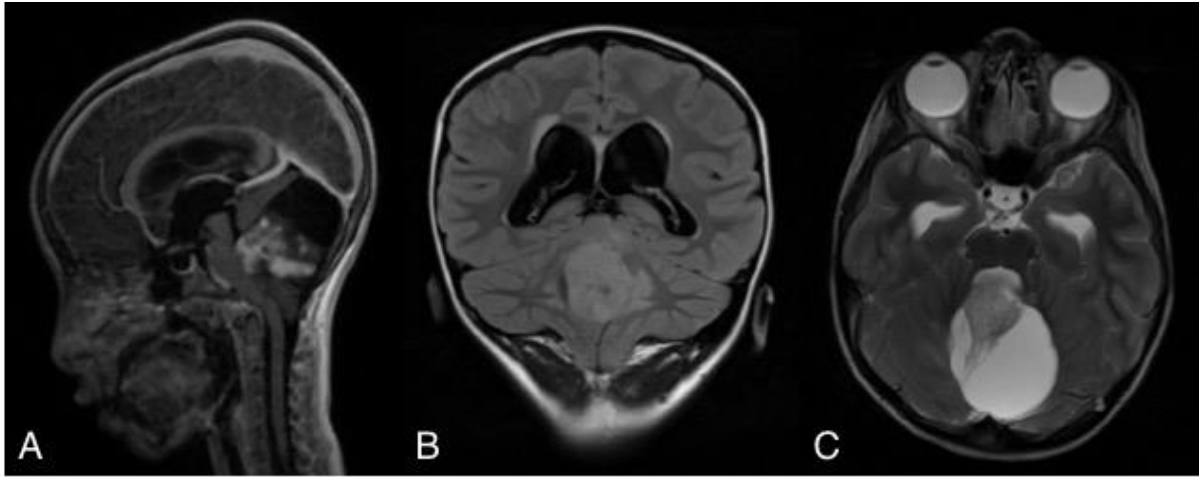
Conventional structural MRI scans of a patient with pilocytic astrocytoma, treated surgically at our institution, who did not develop pCMS. A, sagittal T1-weighted post-Gadolinium; B, coronal FLAIR; C, axial T2-weighted sequences. Note the rostral location of the tumour in the posterior fossa, elevation of the cerebellar vermis and splaying of the superior cerebellar peduncles in these pre-operative sequences.
